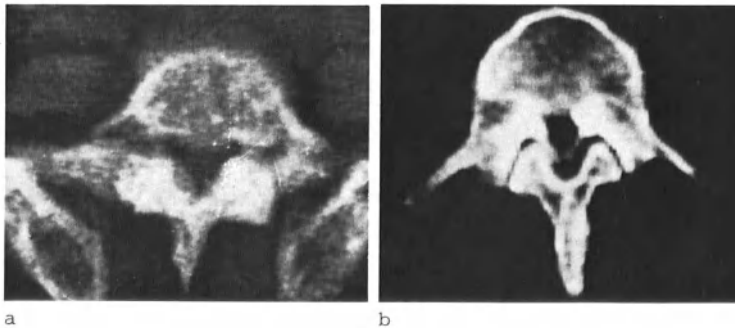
CT section demonstrating spinal canal narrowing: (a) Paget's disease. (b) Achondroplasia
